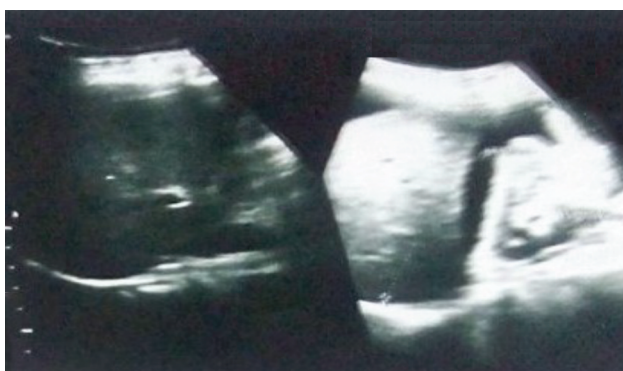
Ultrasonography of abdomen and pelvis revealing a solid- cystic mass in left ovary with ascites.
